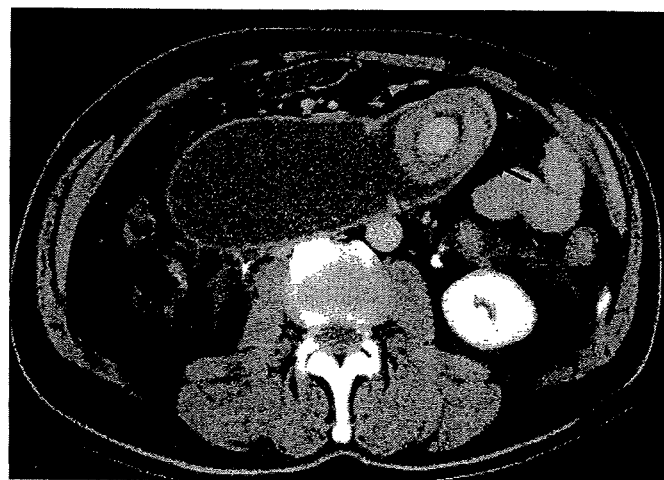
A 5×3 cm lesion with target sign in the proximal segment of afferent loop was identified on CT images (arrows).
